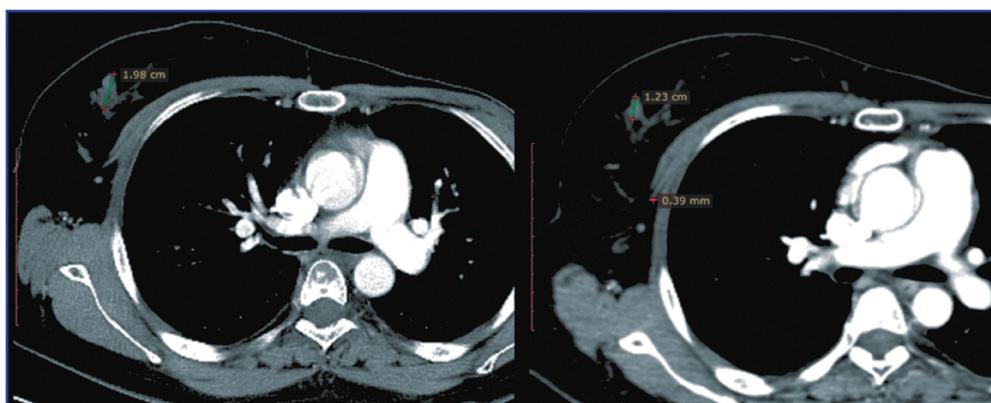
Thoracic Region CT with bolus contrast from July 2018 compared with data from March 2018. The site of RP (radiopharmaceutical) abnormal uptake in the right mammary gland is determined, partial regression of the process (38%).
